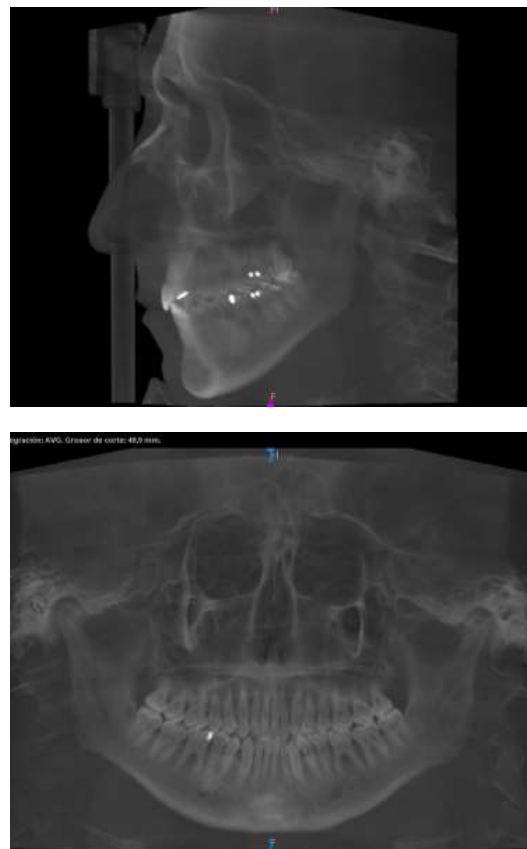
Post-treatment lateral, panoramic radiographs and superimposition
